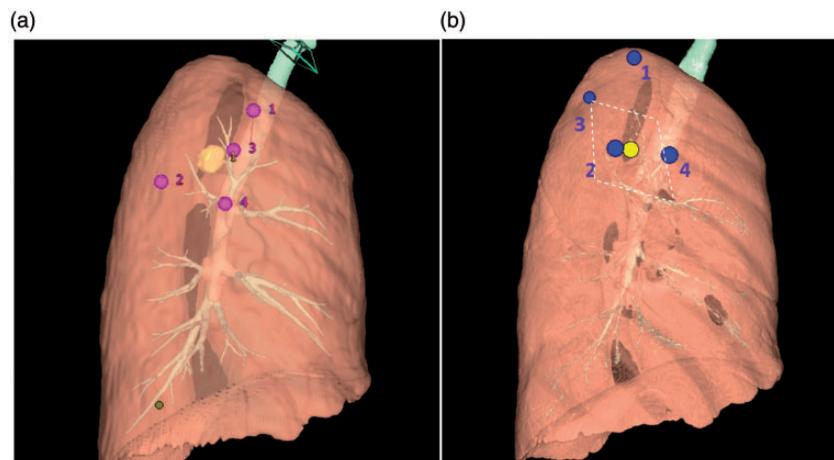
A case of virtual-assisted lung mapping with significant dislocation. (a) Predicted marking points made by mapping mode version 4.3. (b) Actual marking points based on post-mapping computed tomography. Note the dislocation between the predicted and actual markings. The interrupted lines indicate planned resection lines.
